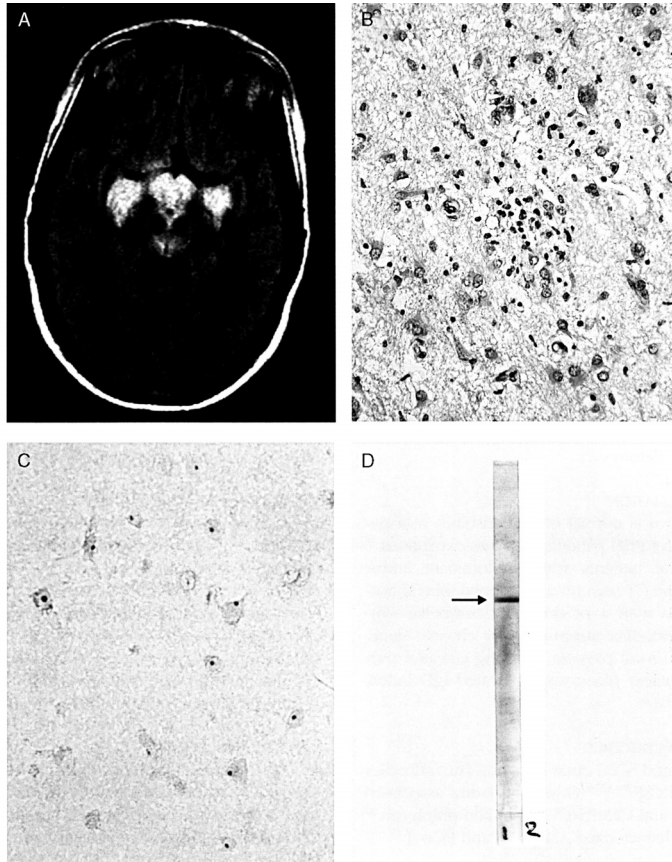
(PLATE 61). Paraneoplastic limbic encephalitis and anti-Ma2 antibodies. (A) MRI shows increased signal intensities in the medial temporal lobes, diencephalon and brainstem (FLAIR). (B) At autopsy, the medial temporal lobe showed parenchymal inflammatory infiltrates, consisting mostly of mononuclear cells. (C) The patient's serum, when reacted with human cortex, showed strong immunoreactivity against neuronal nucleoli. (D) The patient's serum (lane 1) contains immunoreactivity against purified Ma2 fusion protein (arrow). Control serum (lane 2) is negative.
